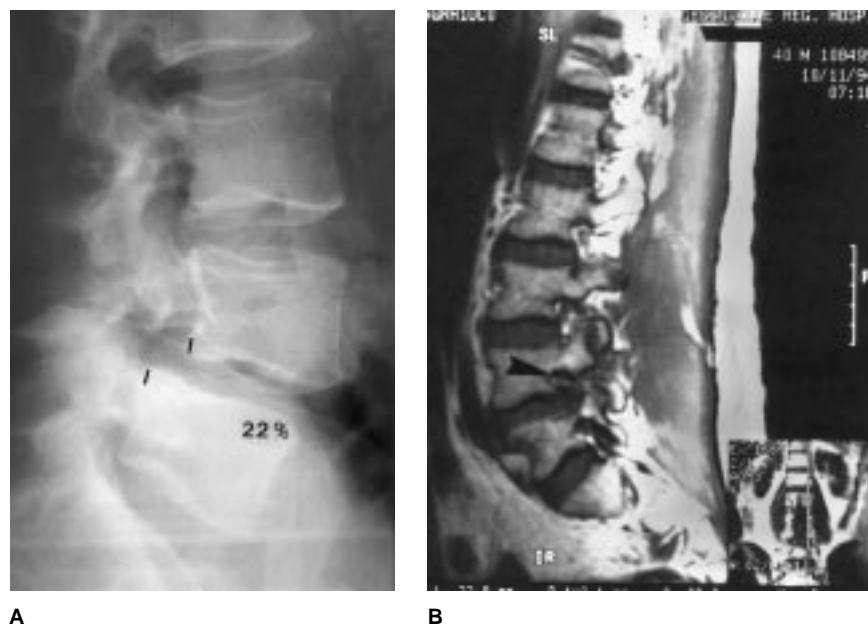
Plain lateral radiograph (A) and sagittal MR image (B) of a 39-year-old man with significant bilateral leg pain due to grade I isthmic spondylolisthesis at L4-L5. On the MR image, marked foraminal stenosis (arrowhead) is seen, as well as flattening of the nerve root and loss of perineural fat.
